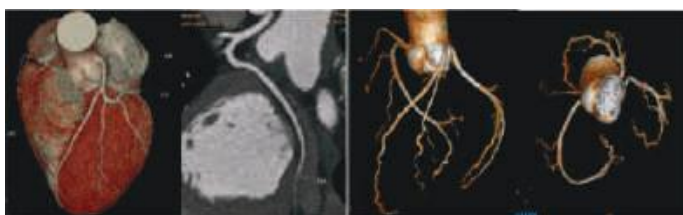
Coronary CT Angiogram – excellent depiction of Coronary Artery Anatomy
